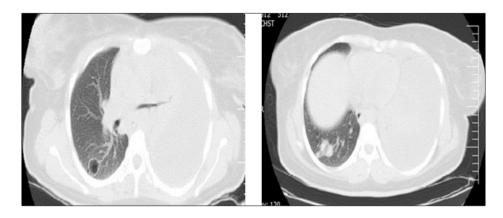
CT-scan of patient with massive pleural effusion during admission
